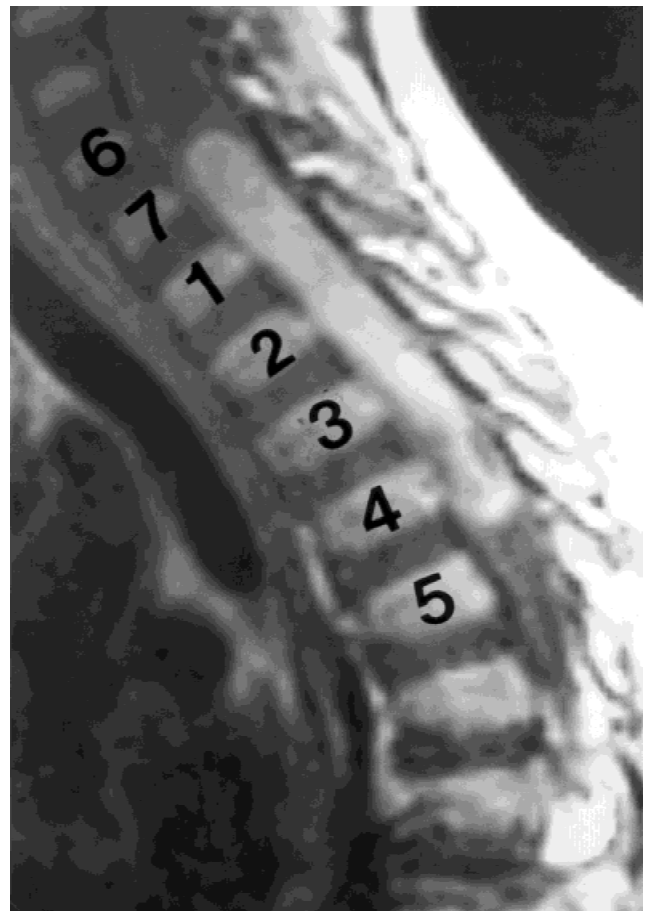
MRI, performed April 15, 1997, showing an increase in tumor volume compared to Figure 1. Vertebral bodies are numbered.
